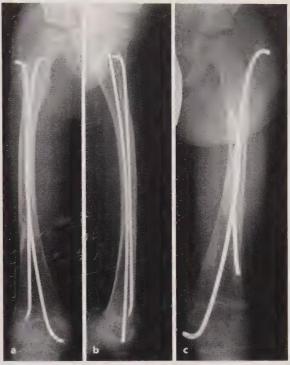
a, b Anteroposterior and lateral radiographs of a femoral telescopic pinning. c Erroneous anchorage of pin extremities into the epiphysis, with protrusion into soft tissue limiting joint mobility
